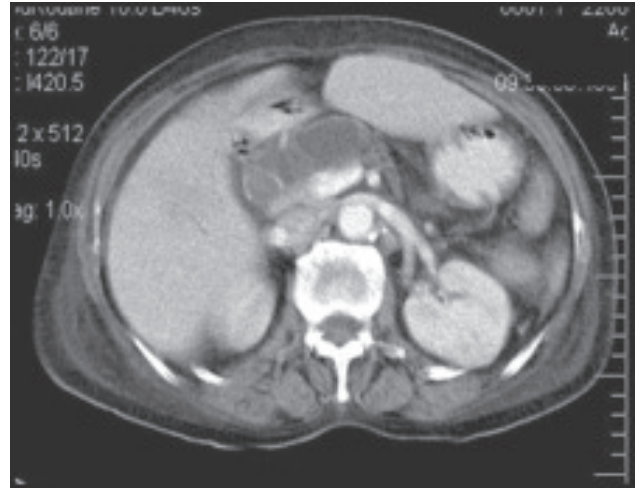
CT-showed mass communicating with pancreatic duct
